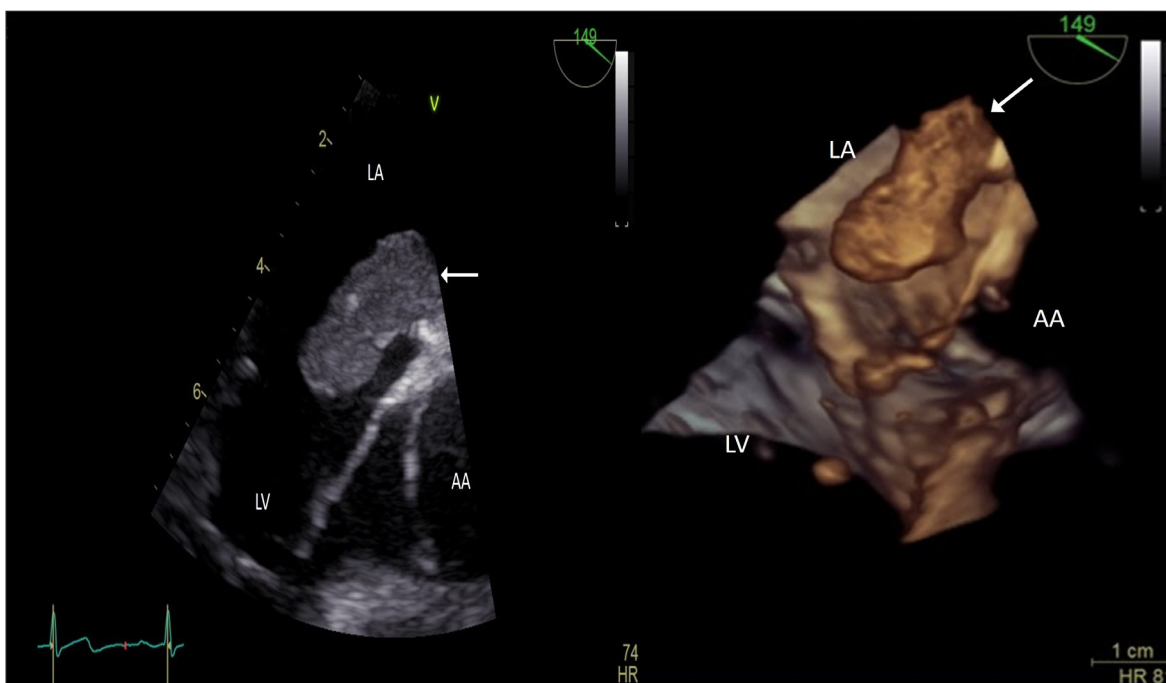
Two-dimensional (left) and three-dimensional (right) transesophageal echocardiography. Large hypoechogenic left atrial mass (←) attached to a PFO occluder. AA – ascending aorta; LA – left atrium; LV – left ventricle.
